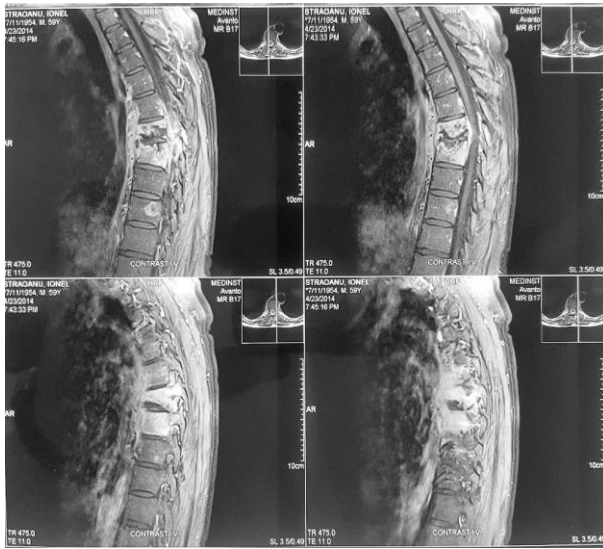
Thoracic MRI with intravenous contrast T2 sagittal plane: T7-T8 osteomyelitis with intraspinal abscess (personal collection).
